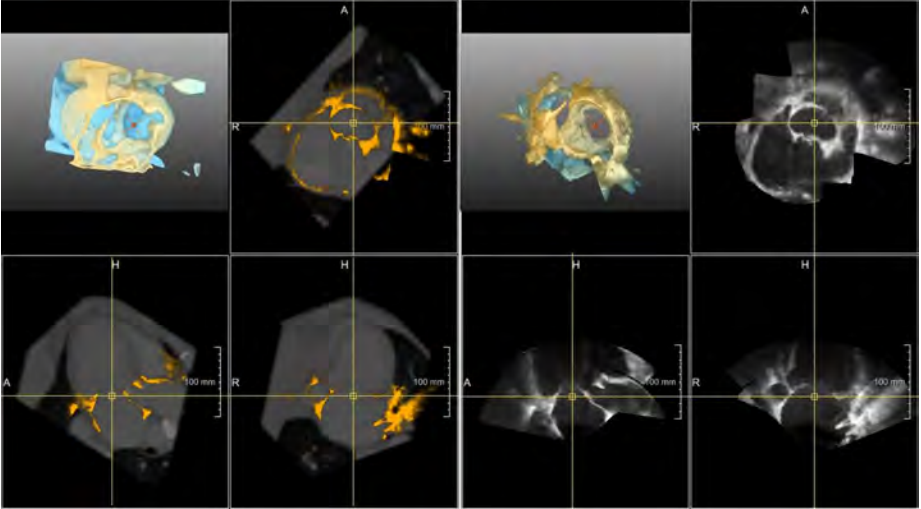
Rendered CTA volume (top left) and rendered fused TEE (top right). The three orthogonal cross sections of the CTA (left) and the fused TEE (right) are shown as well. The marker in the 2D views (yellow cross) indicates the center of the mitral valve. The same location is shown in the 3D rendering indicated by the red cross. Please note the good anatomical correspondence between CTA and TEE. This can be appreciated in the 2D CTA cross sections (left) where the fused TEE is overlaid in orange.
